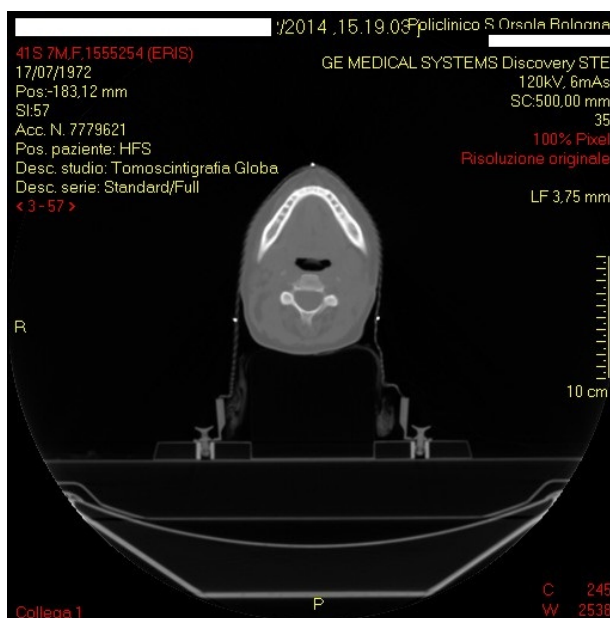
Slice of a PET/CT examination for radiotherapy planning, where the metal pins placed before the scan are visible as well as the structure of the base plate and the contour of the mask and headrest. This patient was diagnosed with thyroid cancer.
